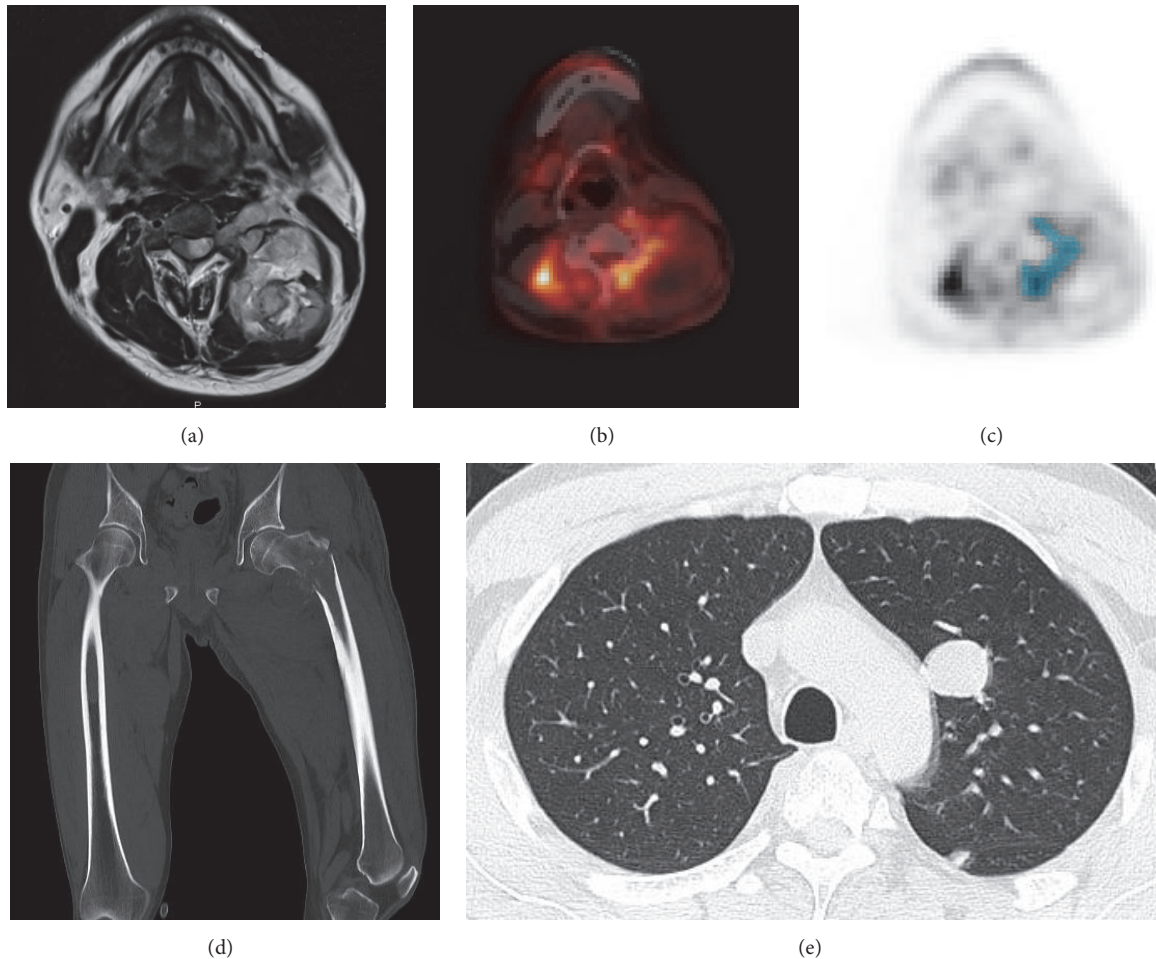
Representative case presentation of  $SUV_{max}$  and metabolic parameters in large and heterogeneous cervical spinal tumor. A spinal MPNST in a 40-year-old man. (a) The mass was 9 cm in size and the axial T2-weighted MRI showed mixed intense signal mass with unclear boundary in epidural and paravertebral space. (b) A preoperative  $^{18}\text{F}$ -FDG PET/CT scan was obtained and the tumor showed moderate  $SUV_{max}$  (5.25 g/mL). (c) For calculations of metabolic parameters, a volume-of-interest was drawn on the PET images (light blue area). A preset threshold of 2.5 of SUV of the tumor was used to define the MTV (84.3 mL) and the mean SUV of the MTV was determined ( $SUV_{mean}$  3.06 SUV). MTV and  $SUV_{mean}$  were used to calculate the TLG (258 SUV\*ml). The patient underwent a partial resection of the epidural tumor and carbon-ion radiotherapy. Five months after surgery, multiple bone (d) and lung metastasis (e) were detected and the patient died 9 months after surgery.
